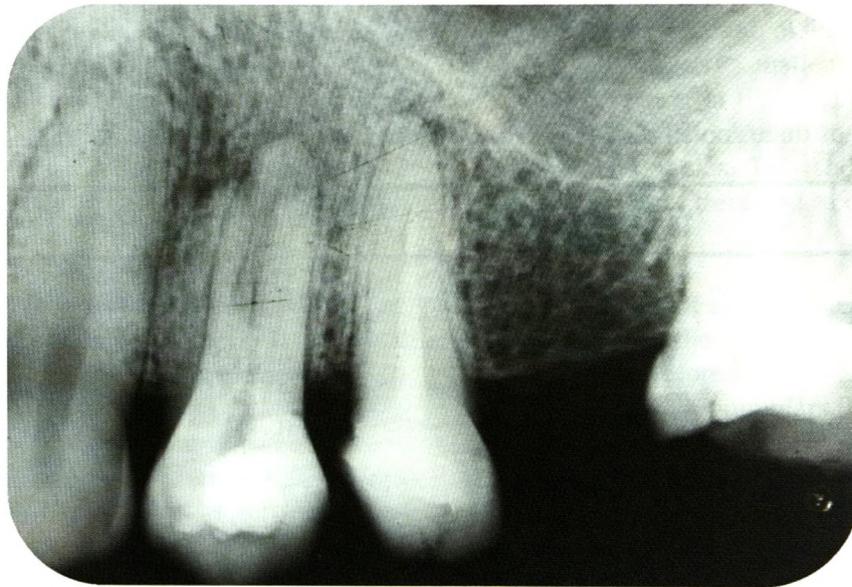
Periapical radiograph to show the tree rooted nature of the tooth.
